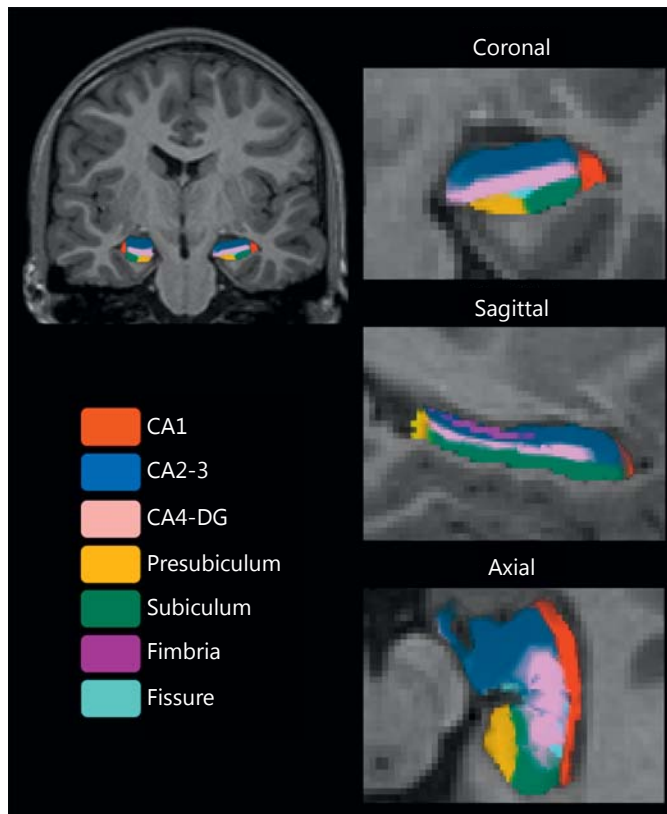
Hippocampal subfield segmentation. The results of the automated subfield segmentation for 1 subject, a 13-year-old female, superimposed on the subject's T1-weighted scan in coronal, sagittal and axial views. The bright yellow posterior section seen in the sagittal slice is the tail of the hippocampus where the delineation no longer discerns between the different subfields. Fissure = Hippocampal fissure.
